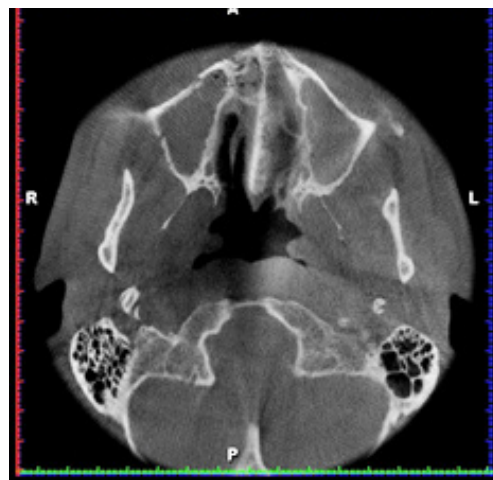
Opacification of both maxillary sinuses on CT scan
